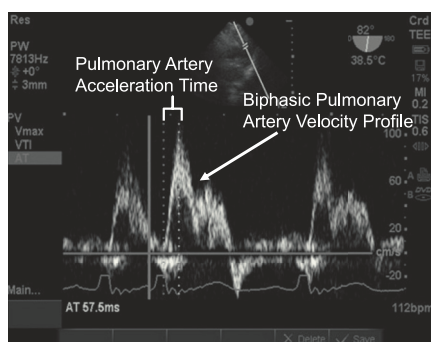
Transesophageal echocardiographic view of the main pulmonary artery with the PW Doppler echocardiography sample volume placed in the main pulmonary artery. The acceleration time is 57.5 ms, and there is a biphasic contour to the velocity profile, suggesting the presence of pulmonary arterial hypertension. AT = acceleration time; VTI = velocity time integral. See Figure 2 legend for expansion of other abbreviation.
